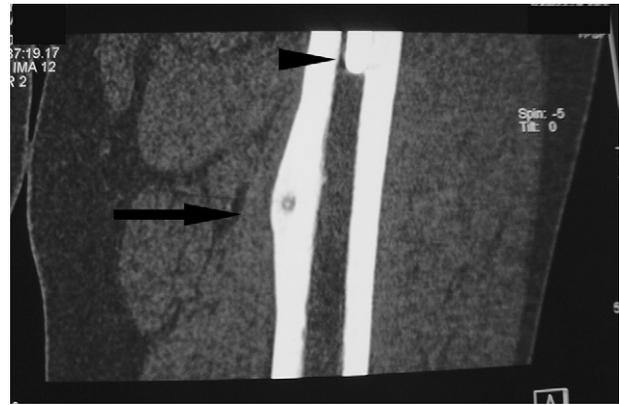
Coronal slices on CT of the left femur. Lucent area surrounded by reactive bone formation suggesting osteoid osteoma (arrow) below a hip prosthesis (arrow head).
